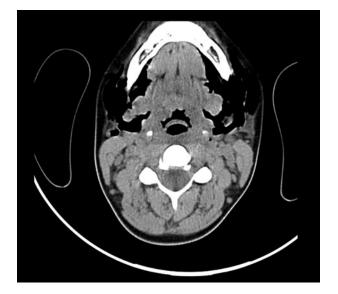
Axial computed tomography scan of the neck showing bilateral cervical emphysema.
